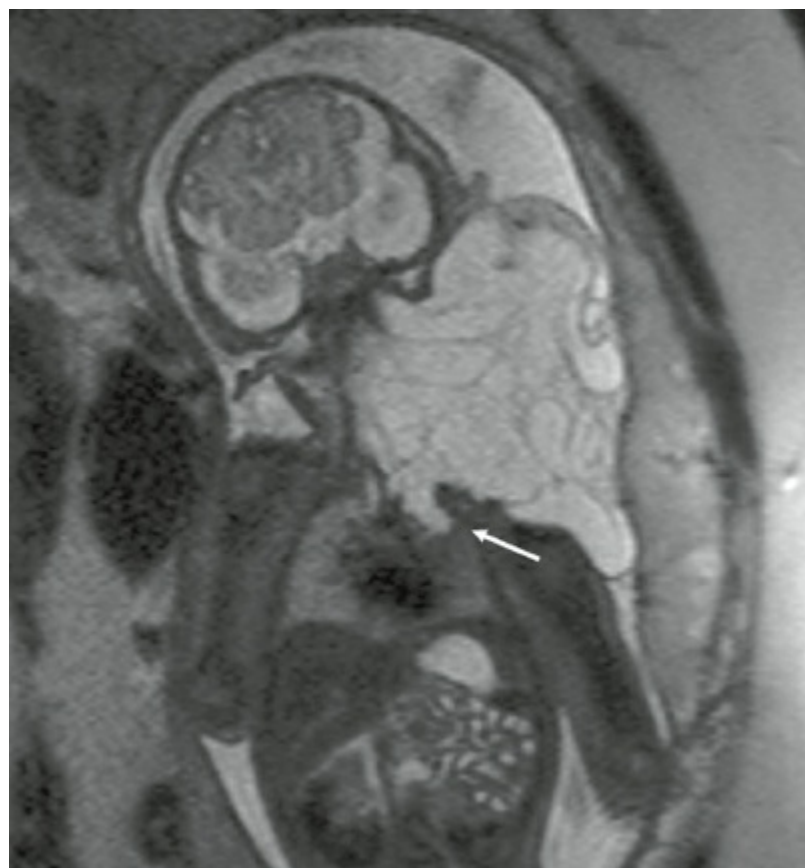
Coronal section of a fetal magnetic resonance image (MRI) of a 31-week fetus with a large left neck lymphatic malformation. The mass extends to the apex of the left chest (*arrow*). There is moderate left-to-right tracheal deviation. This fetus was delivered with an ex utero intrapartum treatment (EXIT) procedure.
